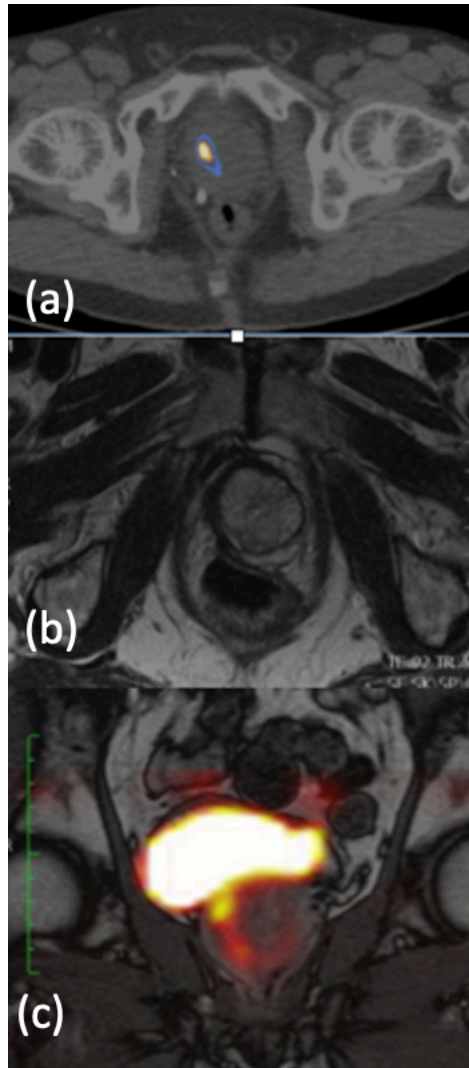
(a) Axial ^{18}F Choline PET/CT demonstrating focal area of apparent increased uptake in the right lobe of the prostate gland. Axial MRI showed post HIFU changes with marked atrophy of right lobe, hypertrophy of the left lobe. Coronal fused PET/MRI showed urethral tract with excreted activity and no evidence of tumour.
